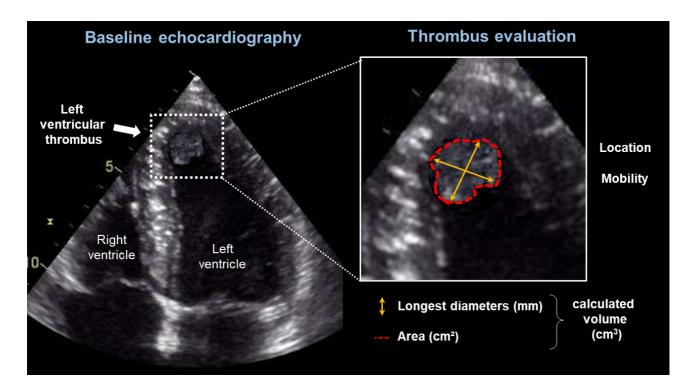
Methodological aspects of left ventricular thrombus echocardiographic evaluation.
